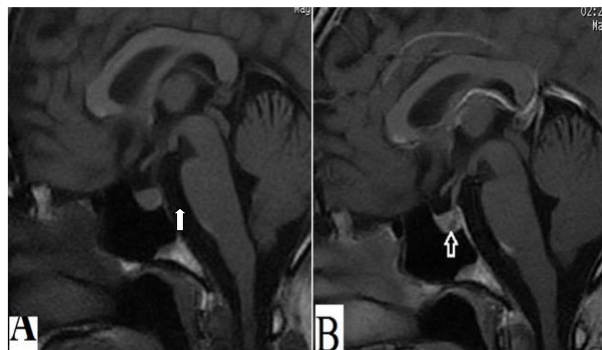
Sagittal T1W MRI (A) and Post contrast mid sagittal section (B) demonstrating an oval shaped non-enhancing isointense lesion in the pituitary gland (white arrows)
